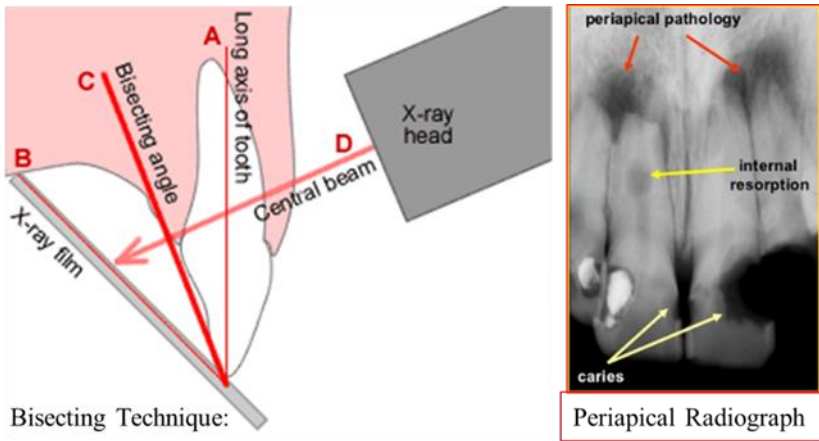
Top left, intraoral bisecting technique. Top right, intraoral periapical radiograph. Bottom, intraoral paralleling technique.
